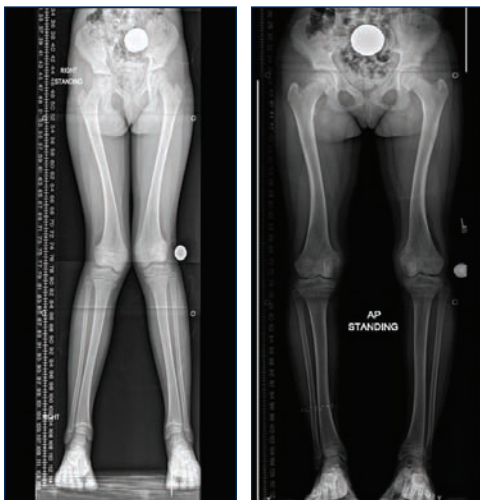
Standing Pre and Post operative radiographs showing valgus deformity and corrected alignment.
